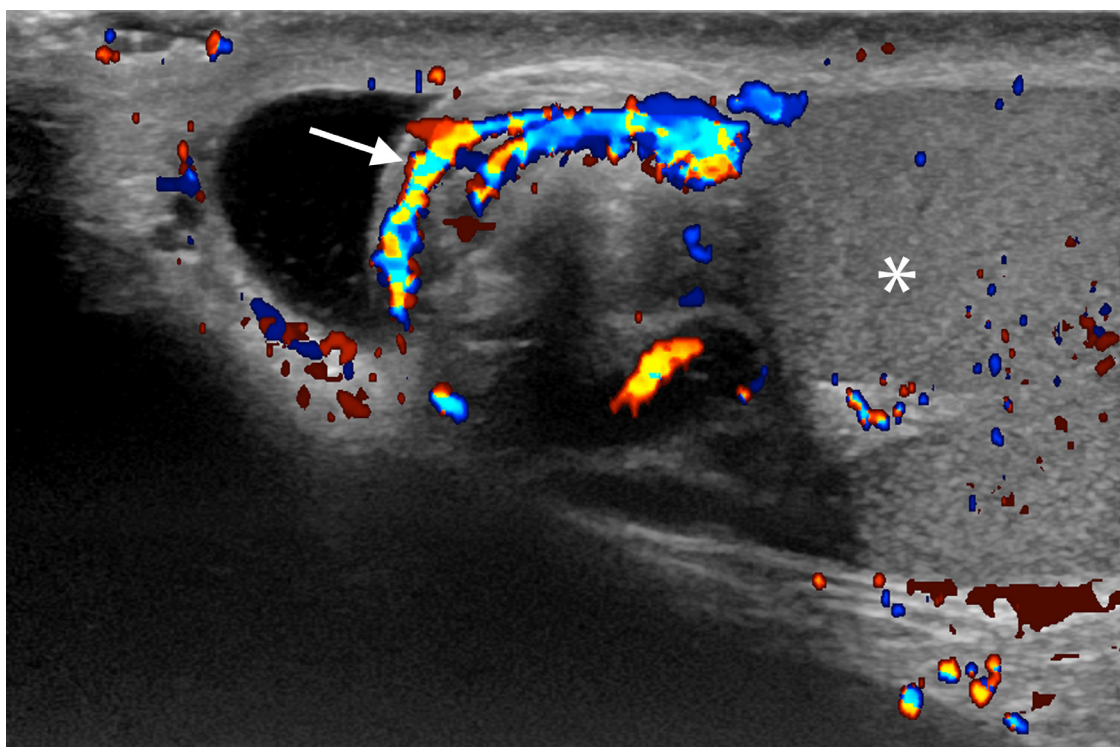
Ultrasound of the spermatic cord demonstrates an edematous, heterogeneous extra testicular mass representing the twisted spermatic cord, with whorled color flow, the “whirlpool sign”(white arrow) around a central axis. Immediately adjacent is the testicle (white asterisk).
